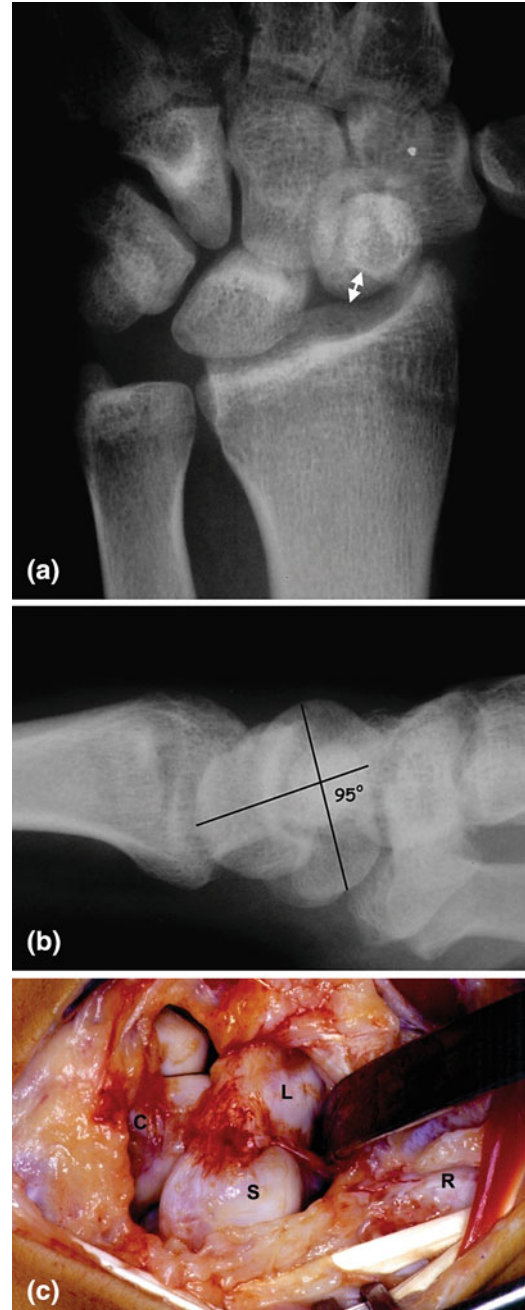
A case with insufficiency of the secondary stabilizers while the primary stabilizers remain relatively intact. Foreshortened scaphoid on P-A radiographs with a positive ring sign (a), increased SL angle (b) and a macroscopically intact dorsal SL ligament (c)
